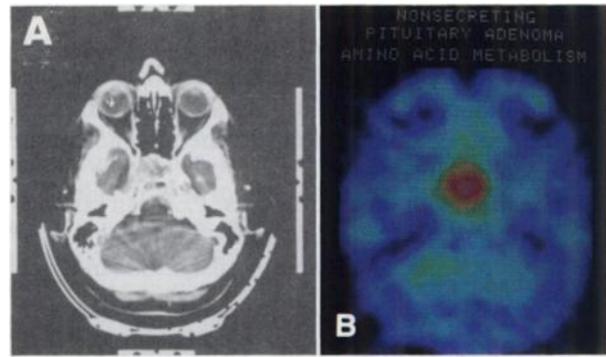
Patient with a non-secreting pituitary adenoma, operated several years ago. Now referred again because of clinical symptoms of tumor regrowth. CT demonstrates soft-tissue mass in the sella region (A), but the interpretation is complicated because of previous surgery. PET with ^{11}C -methionine (B) shows high localized accumulation thereby proving the diagnosis of tumor recurrency.
